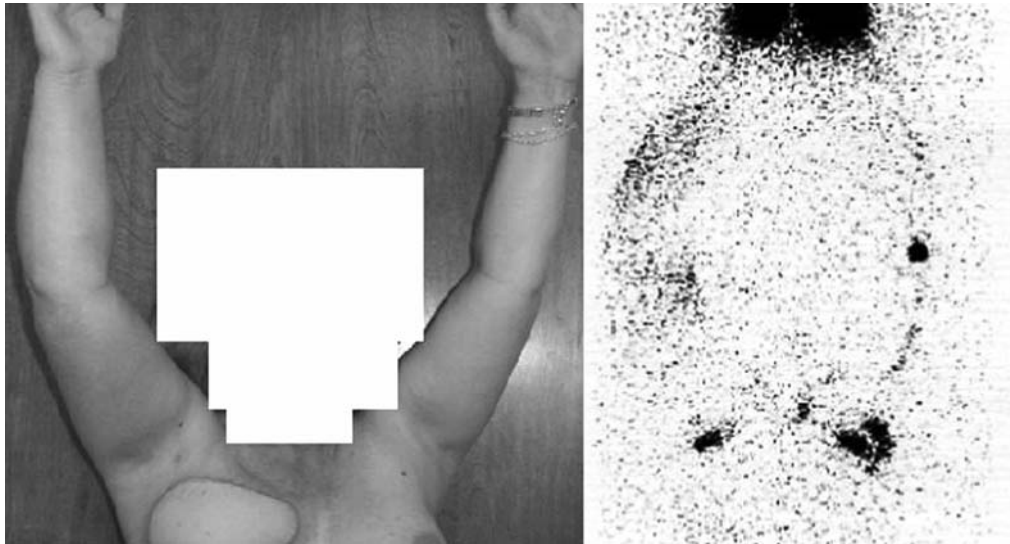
LE of right arm after mastectomy, axillary lymphadenectomy, and irradiation for breast cancer. *Right Panel:* Lymphoscintigram demonstrates dermal backflow and retention even though some right axillary nodes are still present.
